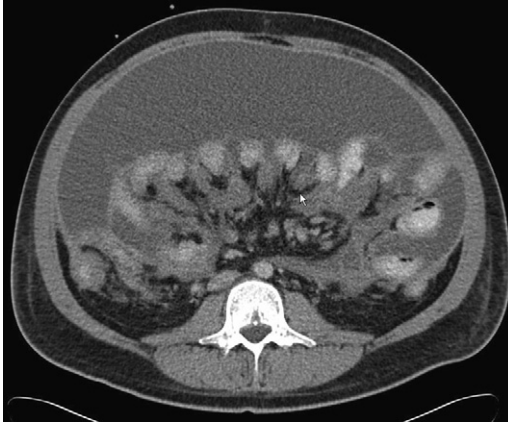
Foreshortened mesentery on preoperative CT scan.
